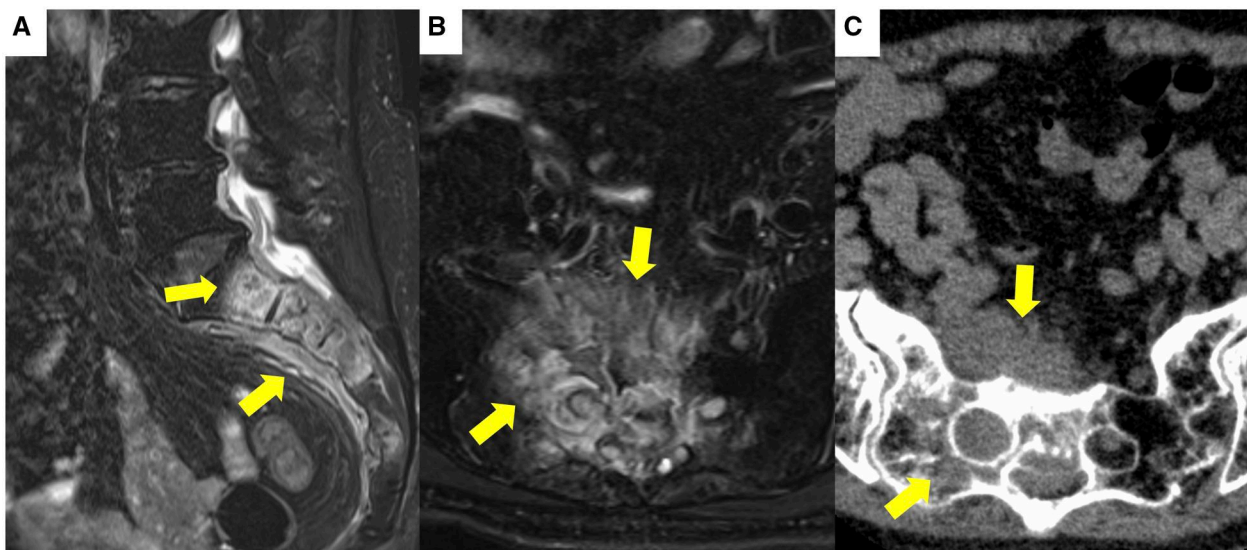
Initial MRI and plane CT examination. T2-weighted Dixon MR sagittal image (A) and T2-weighted axial image (B) showing an intraosseous tumour at the S1-3 level of the right sacrum with an anterior extraosseous extension of the tumour. Planar CT showing an intraosseous tumour in the right sacrum with an anterior extraosseous tumour extension (C).
